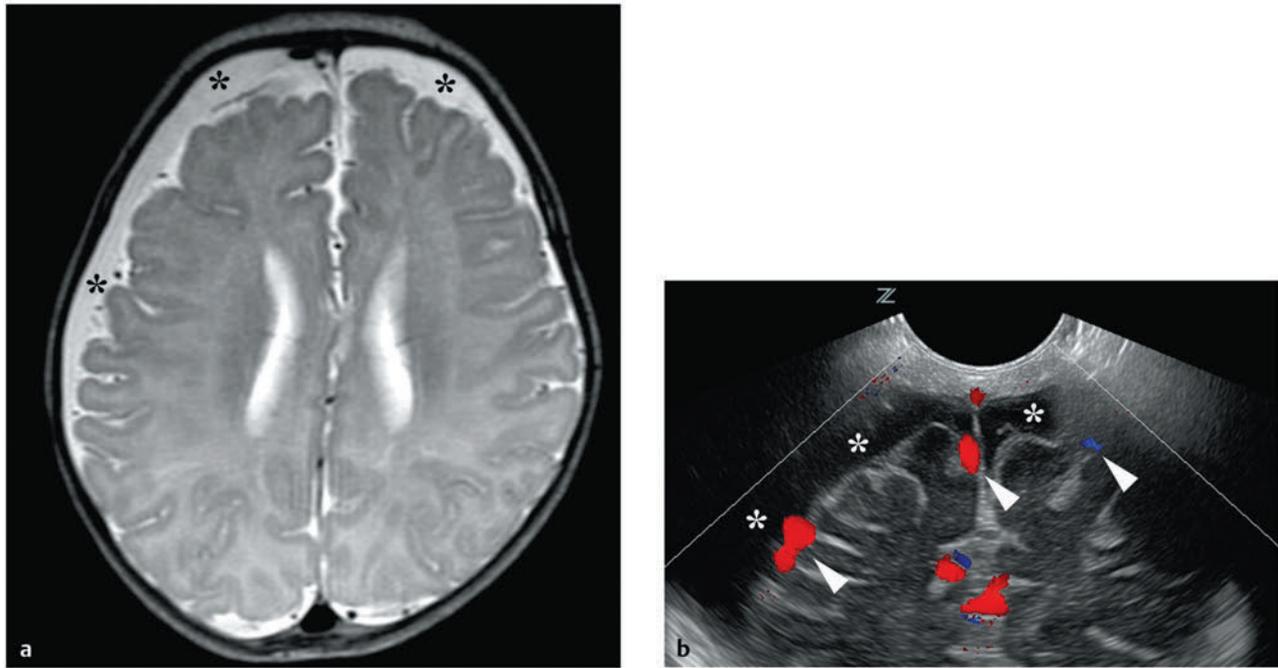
(a) An infant with group B streptococcal meningitis underwent magnetic resonance imaging. This axial T2-weighted image shows bilateral subdural effusions (*black asterisks*). The subdural collections are homogeneous, with signal intensity close to that of cerebrospinal fluid. (b) Ultrasound examination of the brain of the same patient shows hypoechoic extracerebral collections (*white asterisks*), confirmed to be subdural by the close apposition to the cortical surface of the Doppler signals (*white arrowheads*) corresponding to vessels in the subarachnoid space.
